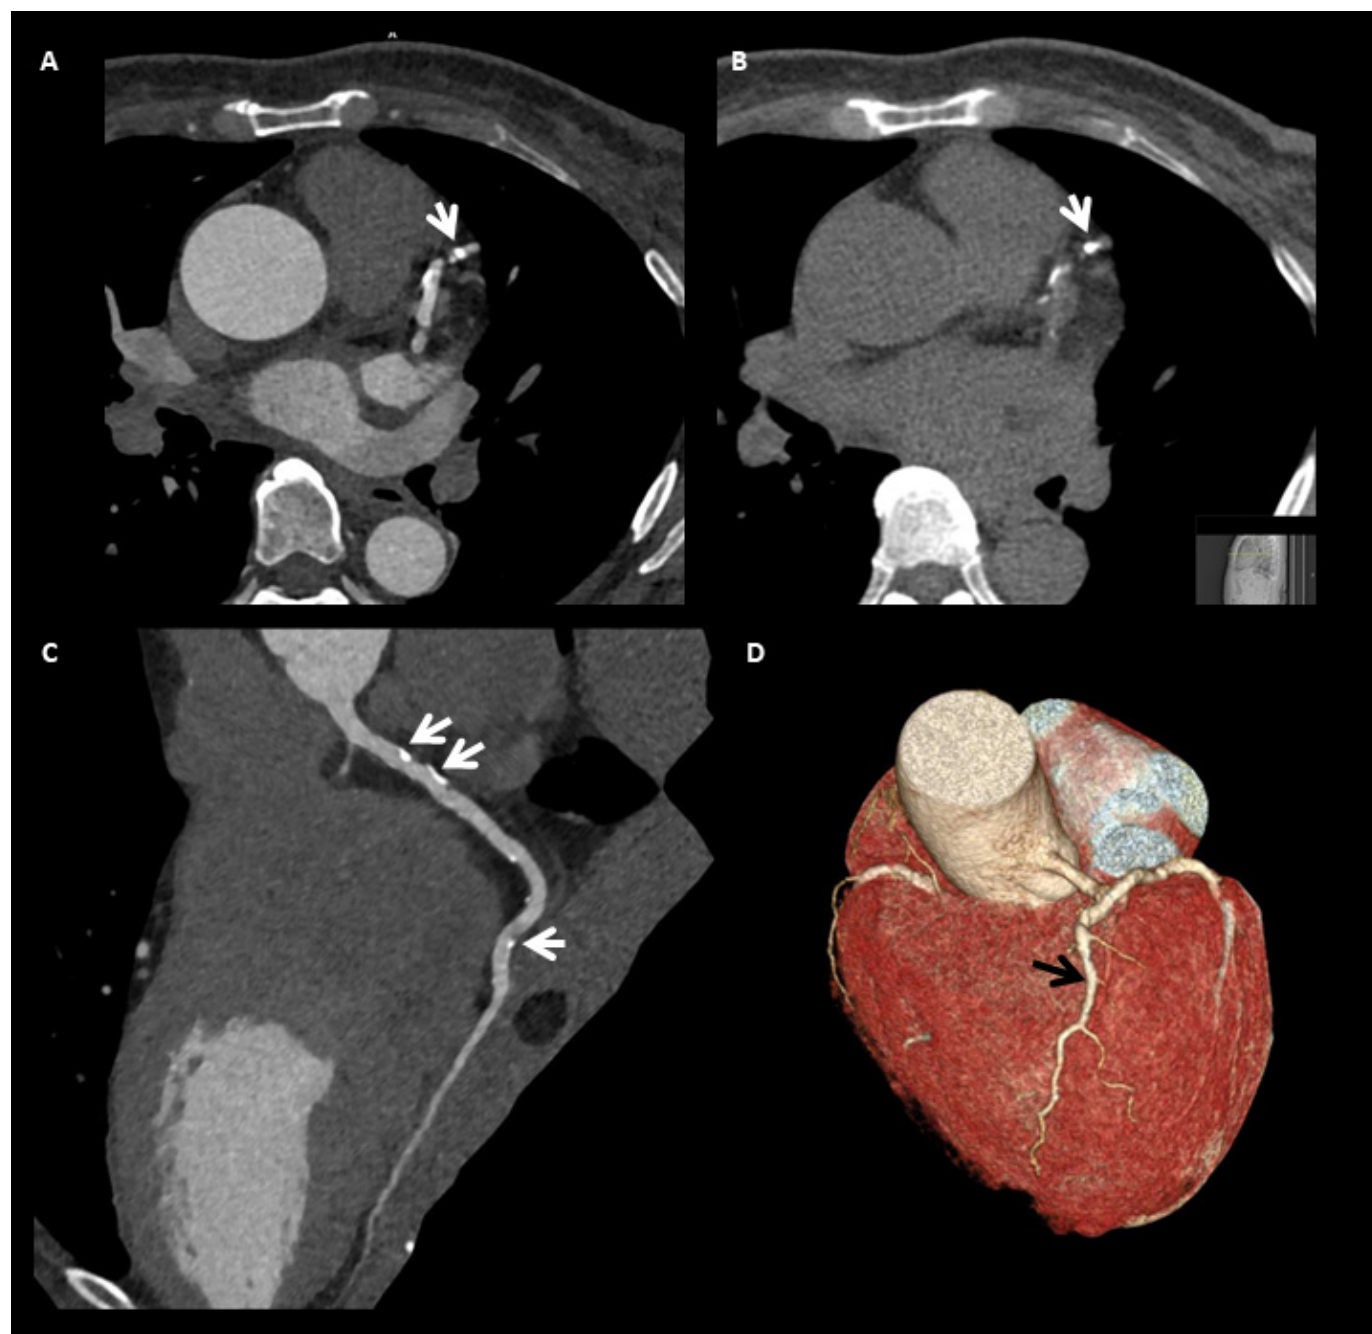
(A) Transverse CTA image of the heart depicting the calcified plaque in the proximal LAD (white arrow). (B) Non-contrast scan of the heart to determine the presence and extent of calcified plaques. White arrow indicates a calcified plaque in the LAD. (C) Curved MPR image of the LAD. The white arrows indicate the presence of calcified plaques. (D) 3D volume rendering image of the heart. Black arrow indicates the LAD. CTA, CT angiography; LAD, left anterior descending artery; MPR, multiplanar reformation.
